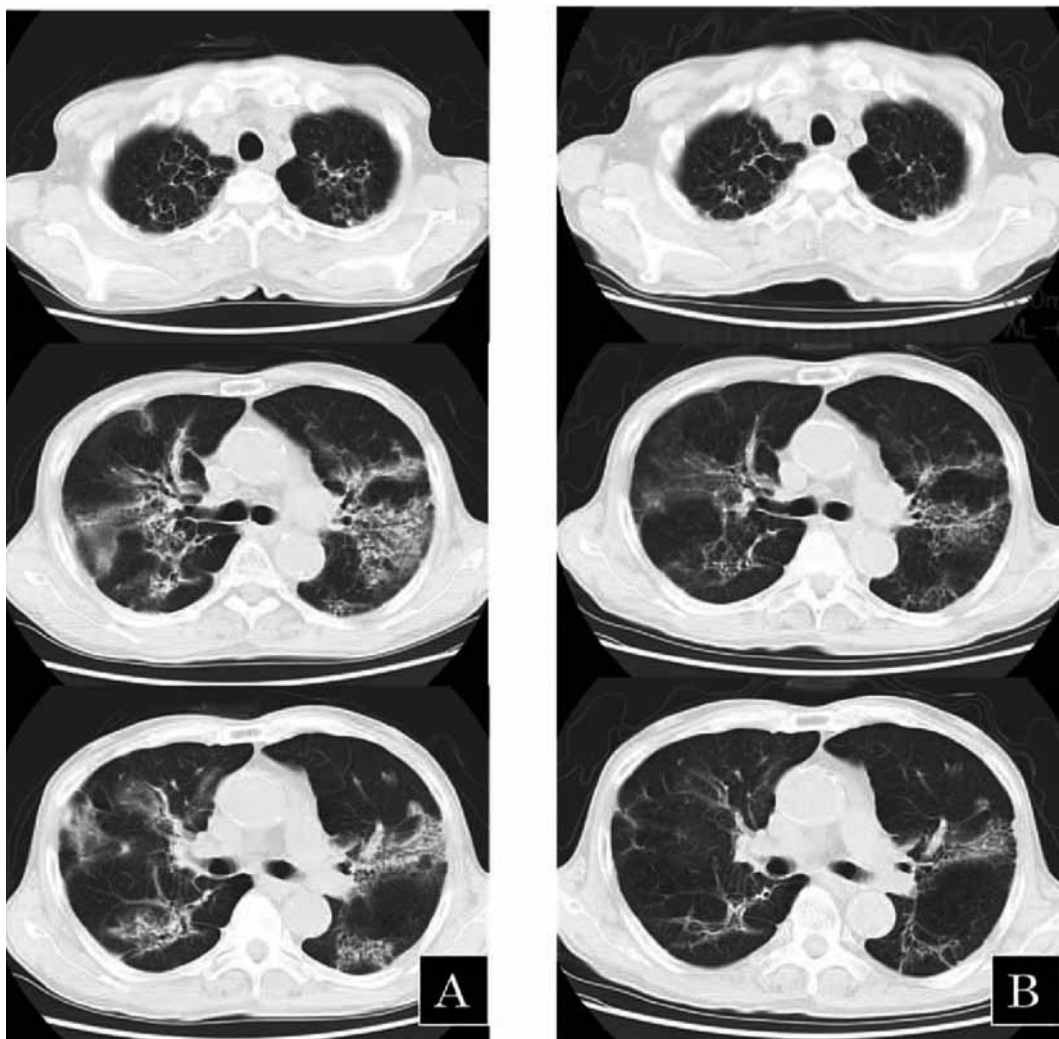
Chest CT images.
